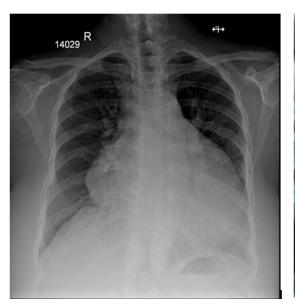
X-Ray Chest PA view showing cardiomegaly with features of heart failure.
